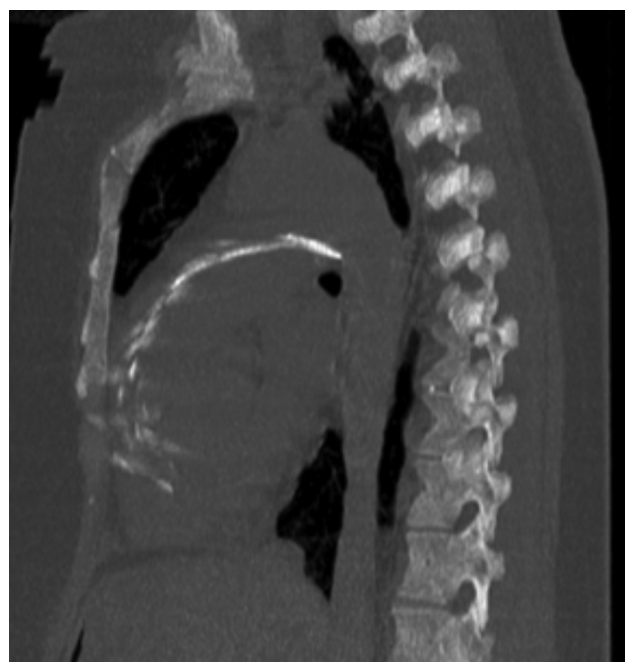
HRCT reformatted sagittal section showing broken PICC line into the right ventricle and extending into the main pulmonary trunk (yellow arrow). HRCT, high-resolution computed tomography; PICC, peripherally inserted central catheter.
